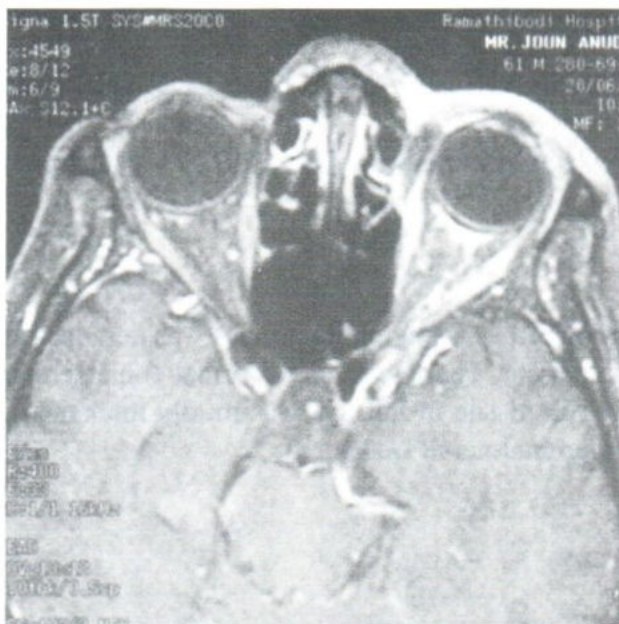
I.V. enhanced axial MRI of the orbits showed abnormally increased enhancement of the intraorbital fat, subcutaneous fat plane over left eye.
